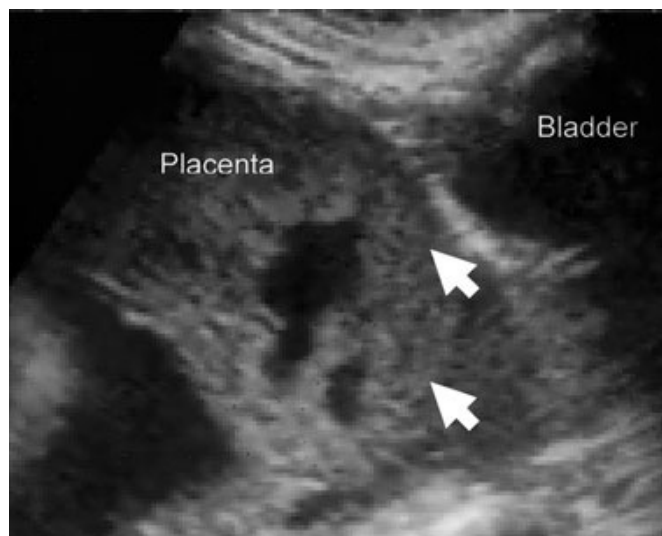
Ultra-sonographic image of placenta previa showing a loss of the Accreta with multiple placental lakes (white arrows).
